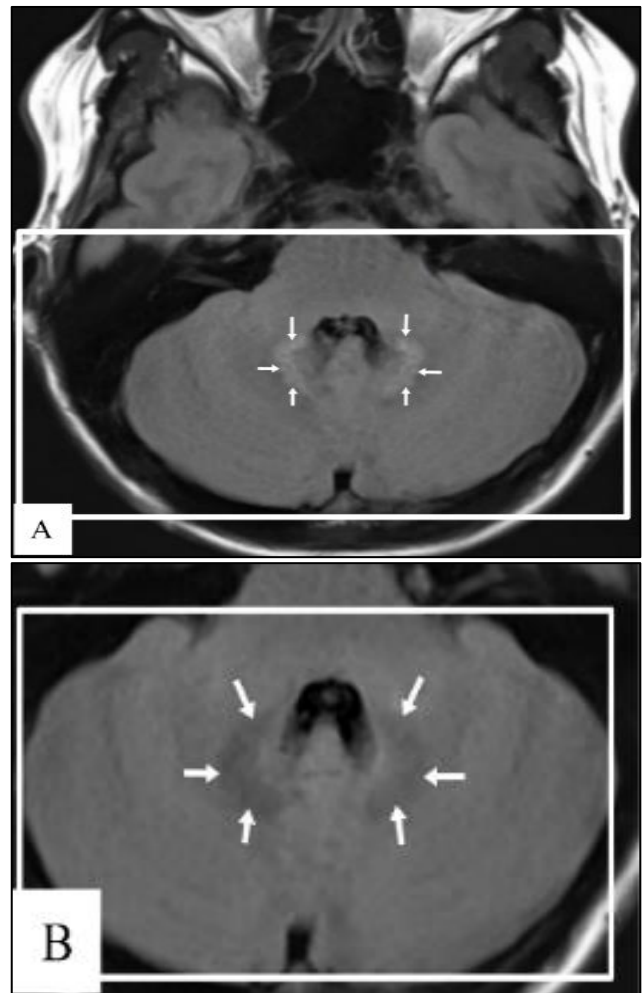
(A and B): Axial fluid-attenuated inversion recovery (FLAIR) MRI of the brain. Exhibits symmetrical increased signal intensity in the cerebellar dentate nuclei (arrows). Exhibits resolution of signal abnormality (arrows).
